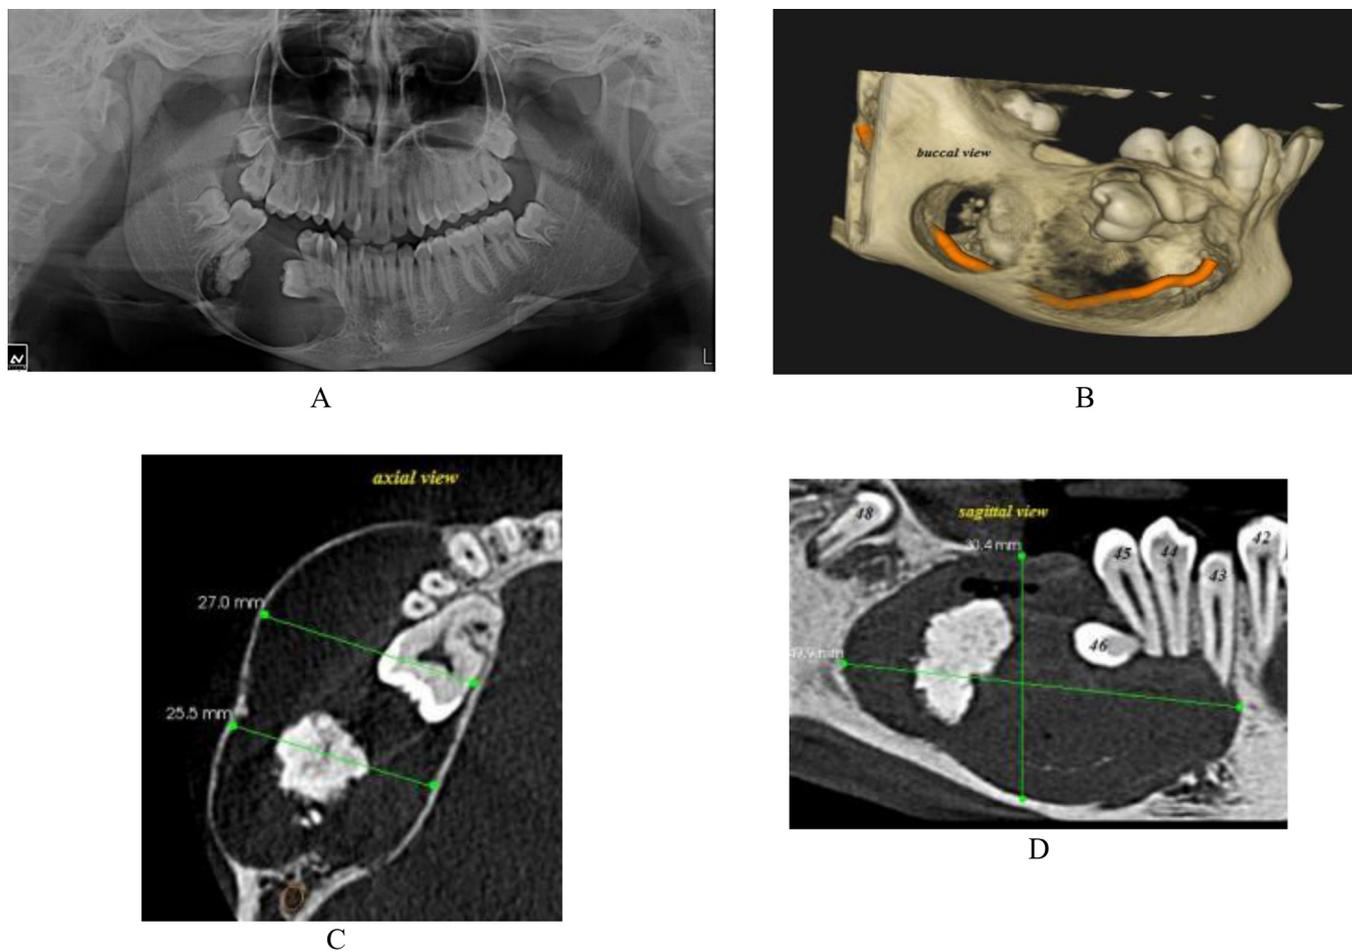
(A) Initial panoramic radiograph. (B) CBCT images demonstrating the buccal view of the lesion. (C) Axial view and (D) sagittal view demonstrating an impacted lower right first molar with mixed radiopaque –radiolucent structure seen lying at distal aspect of lesion.
